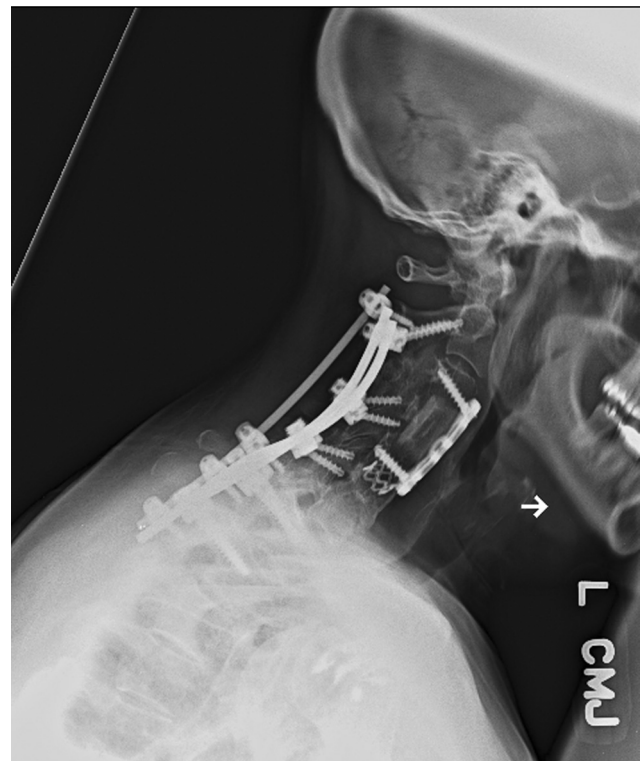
Radiograph was assessed for the neck range of motion by describing the occipitocervical angle made by the anterior border of the cervical fusion mass and the McGregor line and the cervicosternal angle made by the anterior border of the cervical fusion mass and the anterior border of the sternum with the neck flexed.
